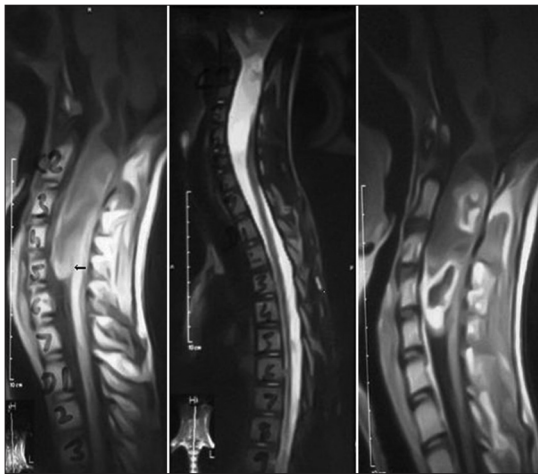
T1 weighted, T2 weighted and post contrast sagittal MRI showing cervico-medullary intramedullary tumour with lower ventral exophytic component
